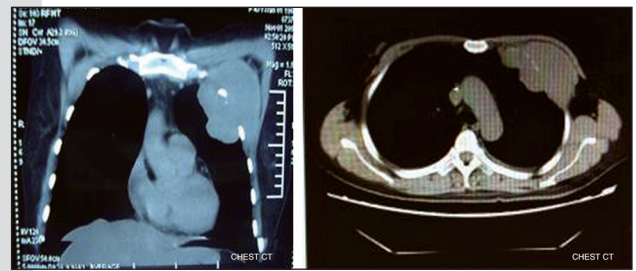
A chest computed tomography scan showed a soft tissue mass in the chest wall
